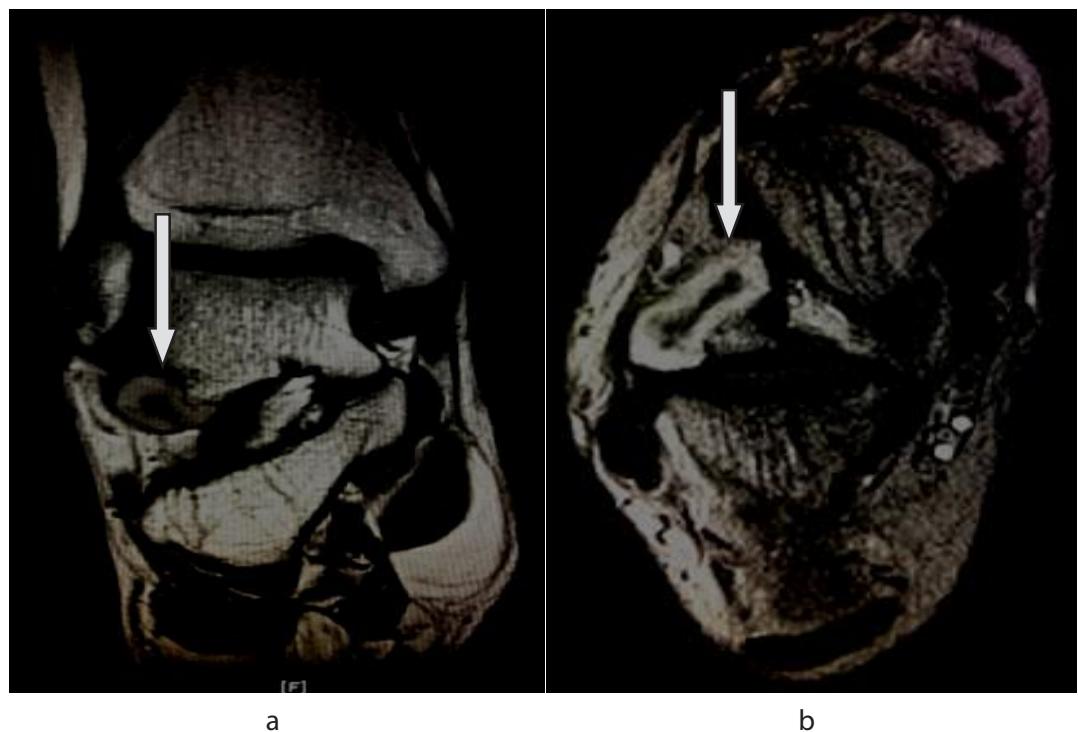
T1 Weighted MRI showing post gadolinium coronal view (a) and axial view (b) of right ankle with peripheral rim enhancement of talar lesion (white arrow)
